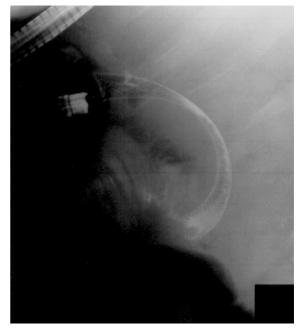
Radiograph of the fully deployed Enteral Wallstent across the duodenal narrowing.
